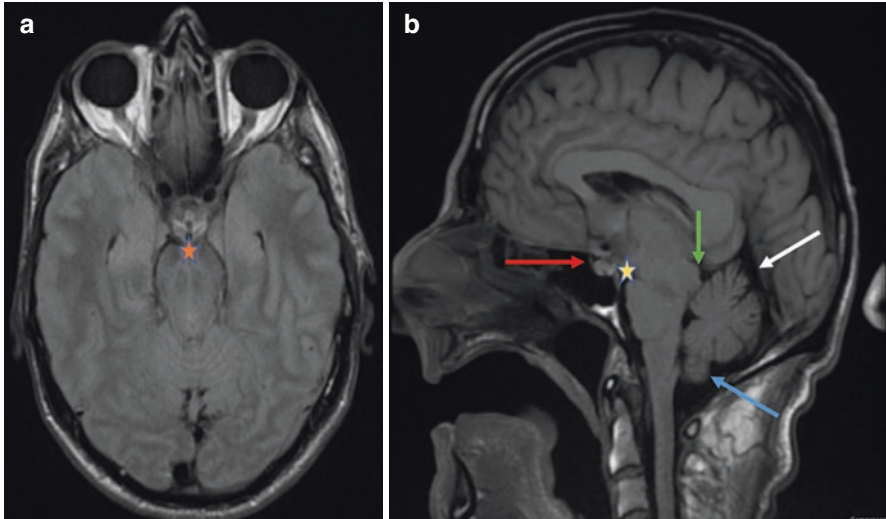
Additional MRI findings associated with intracranial hypotension. (a) T1 axial imaging at the level of the mammillary bodies can show an interpeduncular angle $<40^\circ$ (orange star). (b) Venous engorgement and congestion of the straight sinus (white arrow), tectum displaced below the level of the tentorium (green arrow), cerebellar tonsillar descent (blue arrow), enlargement of the pituitary gland (red arrow), continue flattening with a pontomesencephalic angle $<50^\circ$ and mammillopontine distance less than 5.5 mm (yellow star)
